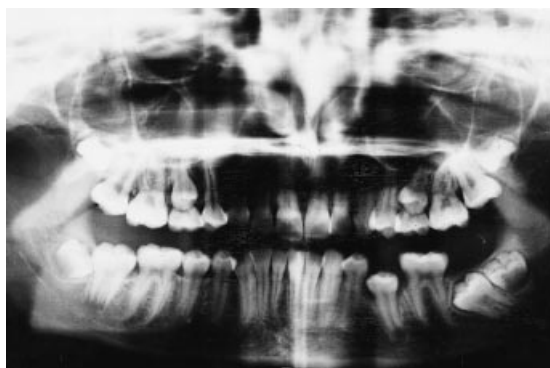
Orthopantomogram of a girl aged 13 years 9 months with arrested eruption of the lower right second molar. Taurodontic root forms are seen on the second molars in the maxilla.
